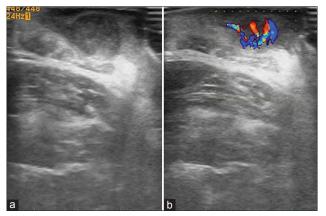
(a) High-resolution ultrasonography of the lesion showed a well-defined hypoechoic round mass lesion in the subcutaneous tissue with hyperechoic center and specks of calcification. (b) Color Doppler study showed increased vascularity in the lesion with branching tree pattern of blood vessels
